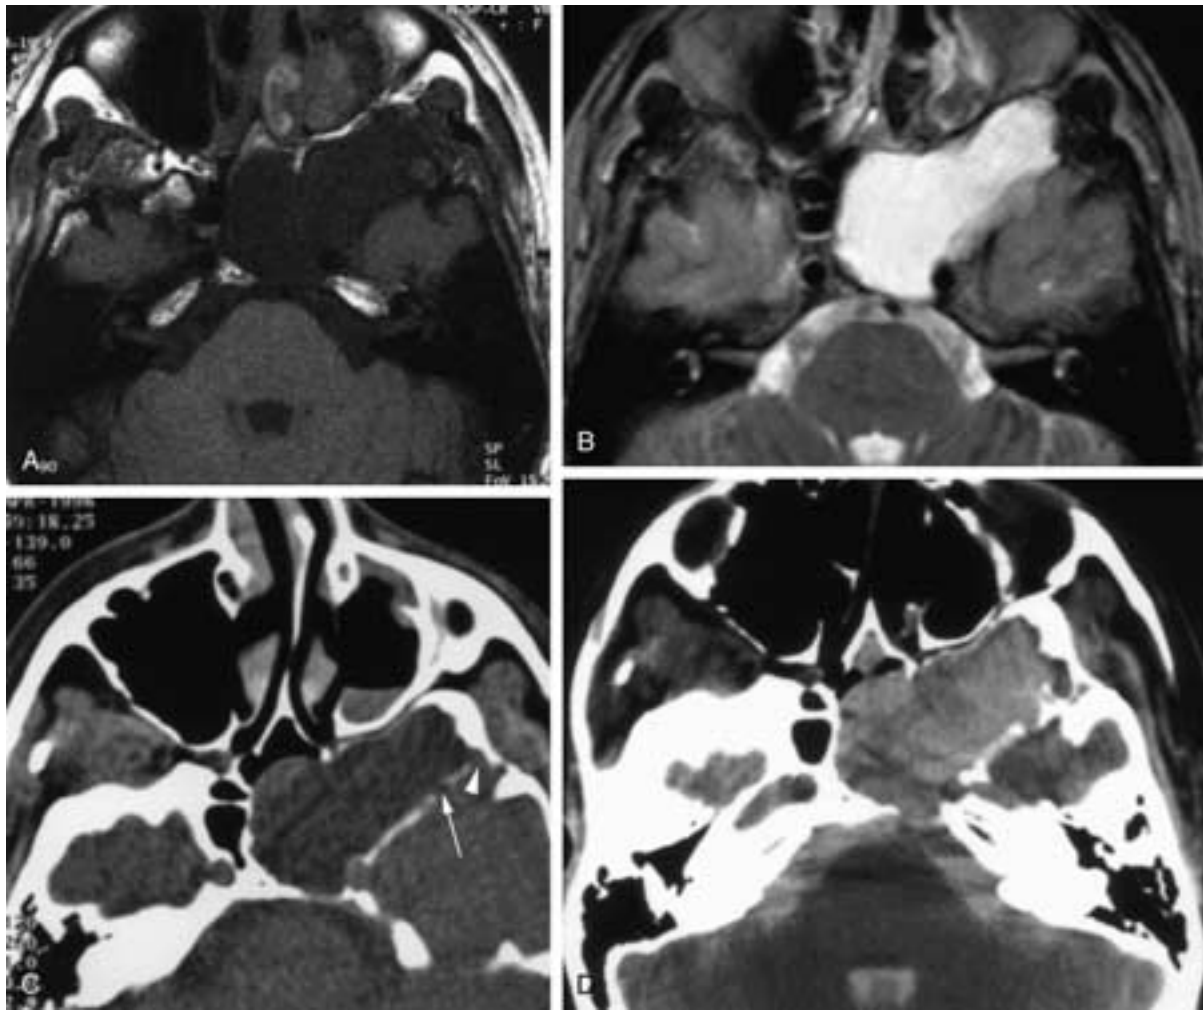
CSF leak into an enlarged sphenoid sinus. A, Axial T1-weighted image shows low signal equivalent to CSF in an expanded sphenoid sinus. The lateral extent of the sinus extends into the medial greater wing at the attachment of the pterygoid process. B, Axial T2-weighted image shows high signal compatible with CSF. C, Axial CT image prior to injection of intrathecal contrast shows a small pit (*arrow*) along the anterior wall of the middle cranial fossa. A small defect (*arrowhead*) appears to extend into the cystic cavity. This may represent extension of arachnoid granulations or a small fracture at that site. D, Postintrathecal contrast image shows filling of the cystic cavity as well as the prepontine cistern and fourth ventricle.
